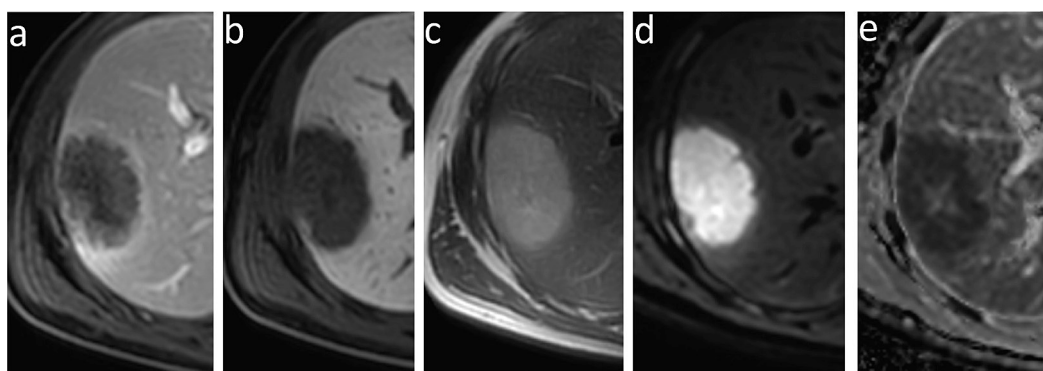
Abbreviations: CRLM colorectal liver metastases, CT chemotherapy, UE unenhanced, T1W T1-weighted, CE contrast-enhanced, AP arterial phase, T2W-SE T2-weighted short echo time.
